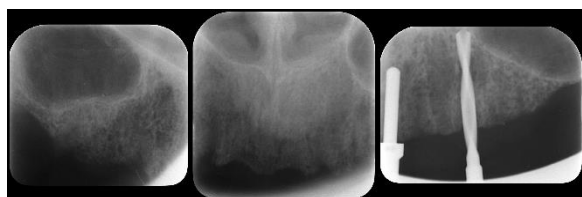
7 Months post-extraction. Clinical and radiographic examination showed a residual maxillary ridge suitable for the installation of 6 endosseous dental implants
